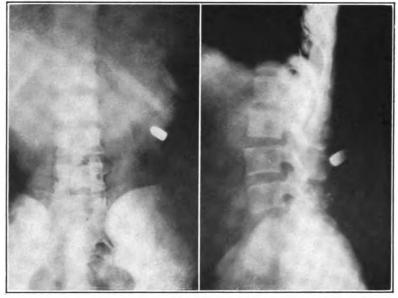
Antero-posterior and lateral roentgenograms of a gunshot injury of the back. The bullet entered on the right side, passed through the spinous process of the fourth lumbar vertebra and lodged in the soft tissues. From these films the bullet could be located so accurately that its removal was easy.
